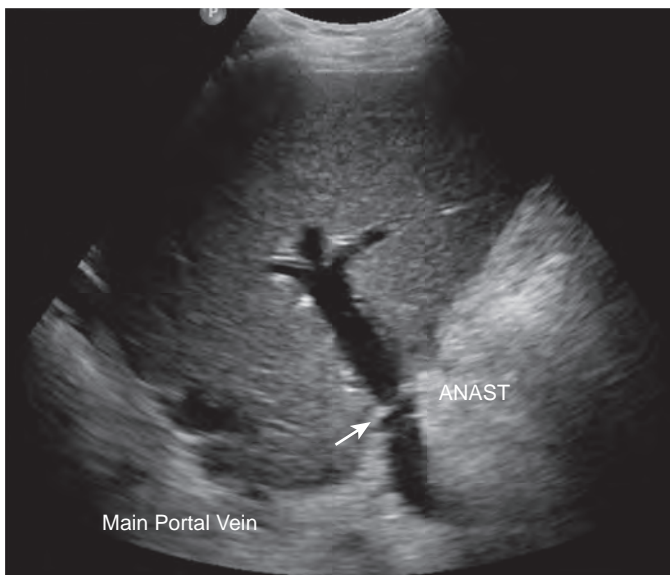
Normal ultrasound appearance of the main portal vein after OLT. An indentation is noted at the anastomotic site (arrow).
